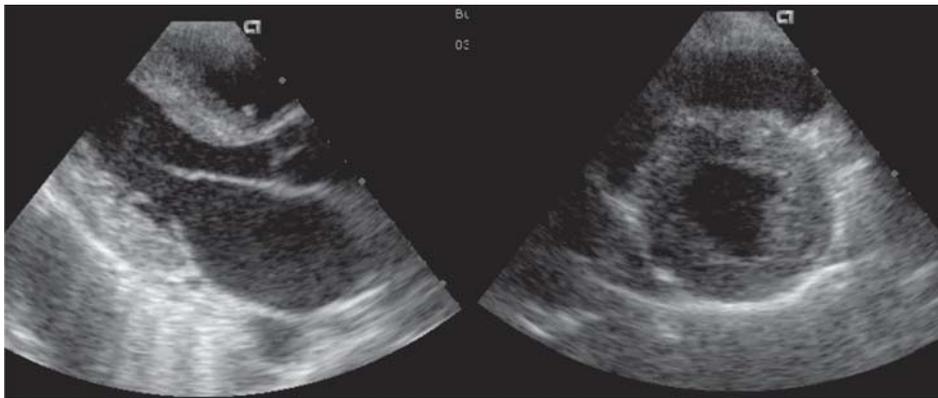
Admission echocardiogram. Pronounced hypertrophy, sparkling-granular appearance of the myocardium, normal left ventricular diameters and left atrial enlargement are observed.
